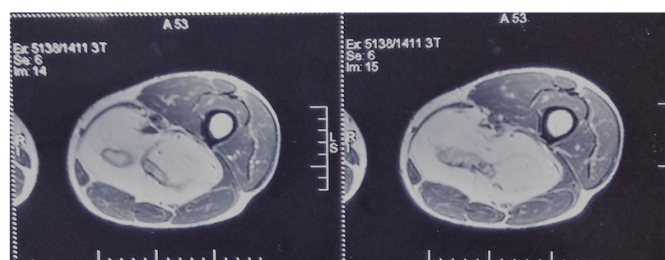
MRI showing displacement of muscles and neurovascular bundle.
